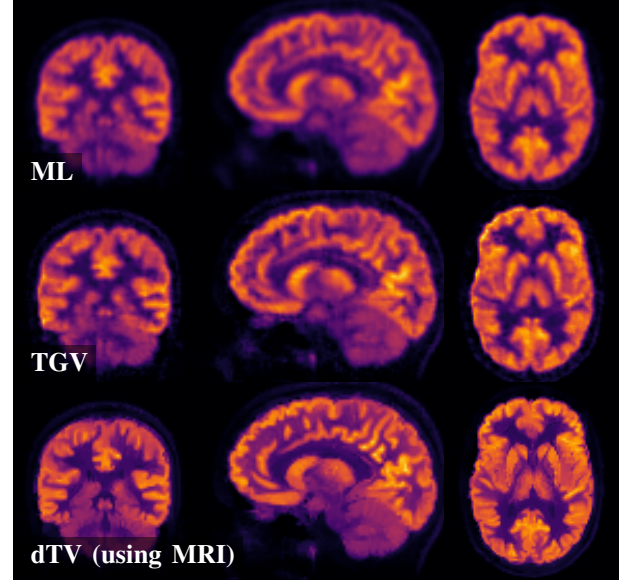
Comparison of several reconstruction approaches for the FDG data. All approaches have about the same computational cost.
